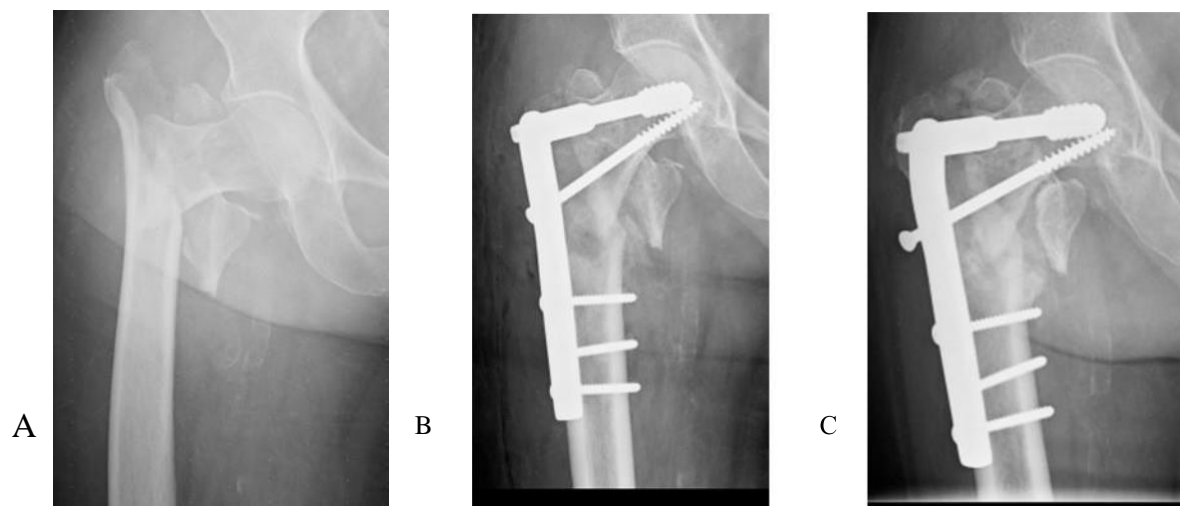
A) 74-year old female patient with a right unstable intertrochanteric fracture B) immediate post-operative x-rays show poor reduction, C) Varus collapse at 3-month follow-up
